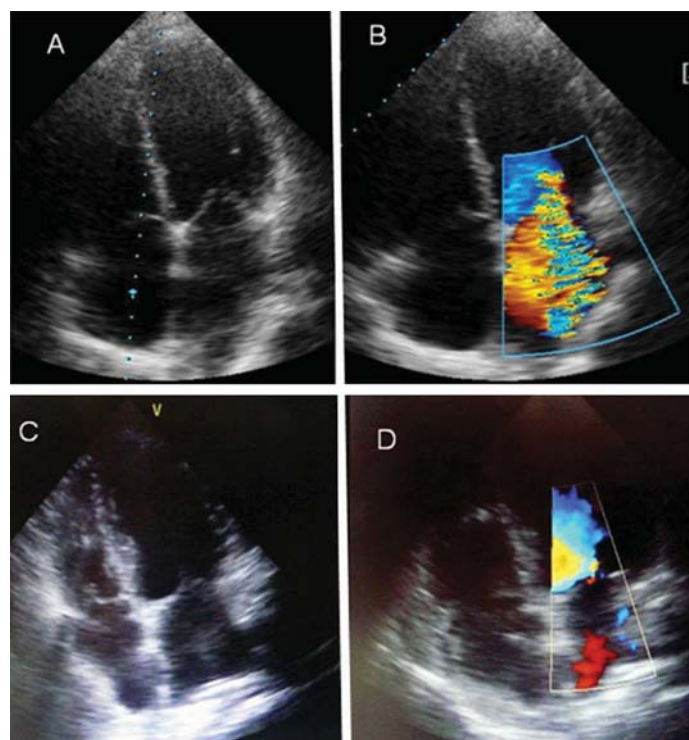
Two-dimensional echocardiogram with colour Doppler flow in the apical four-chamber view showing severe MR during right ventricular apical pacing (*A and B*) and demonstrating minimal mitral regurgitation during RVOT pacing (*C and D*).
